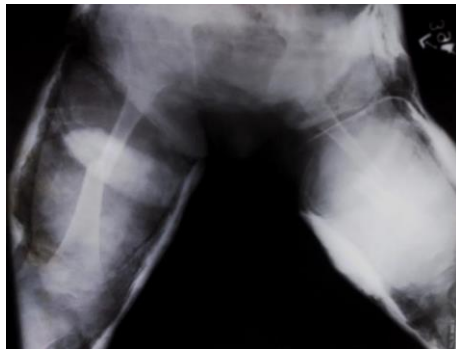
Antero-posterior radiograph of a patient with bilateral femur fracture immediately after hip spica application
